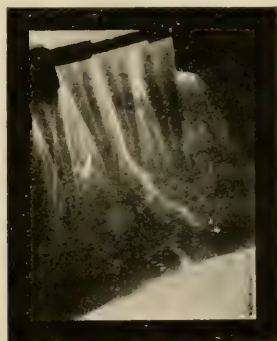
Fracture of the mandible at the symphysis. (Radiograph by Blum, of New York City.)
